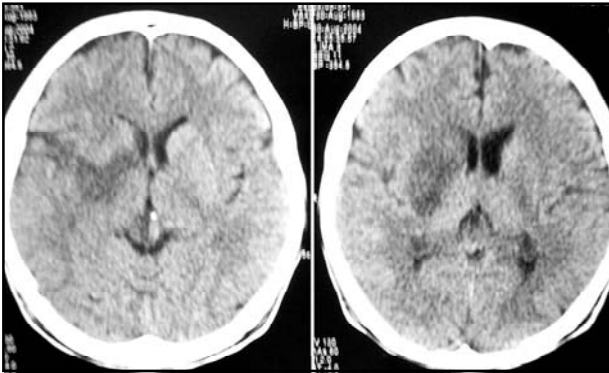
Brain CT: right striatocapsular ischemic stroke.
